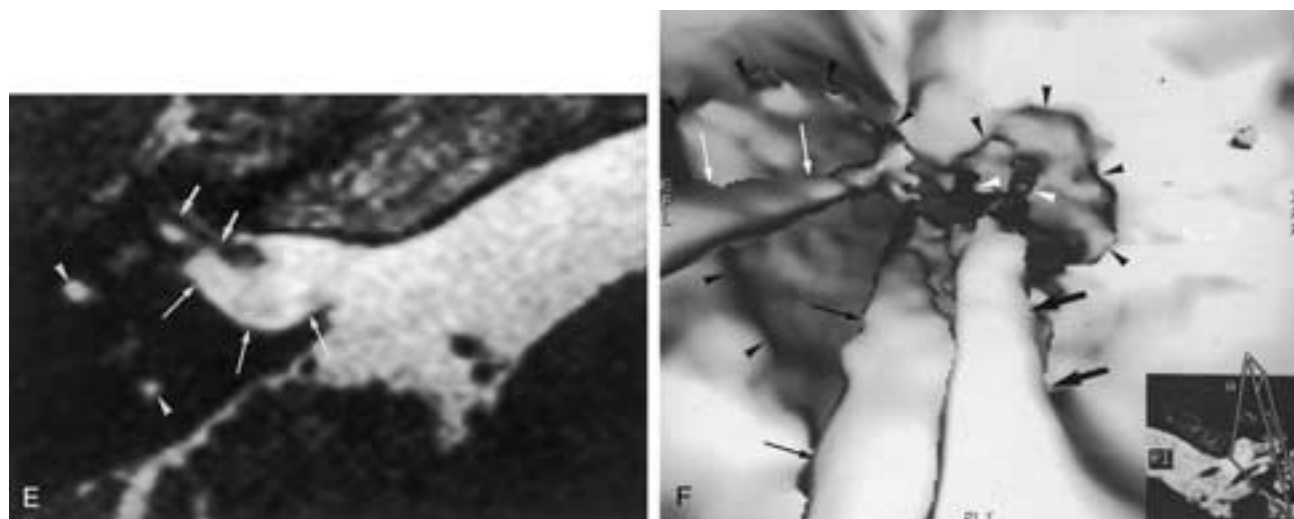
Continued.* E, Axial gradient-echo T2-weighted image through the enlarged labyrinthine segment of the facial nerve canal, confirming the presence of fluid surrounding the labyrinthine segment of the facial nerve (small white arrows). Wide, bulbous IAC (long white arrows) and fluid in the anterior and posterior branches of the superior semicircular duct (white arrowheads). F, Three-dimensional virtual images of the fundus of the right IAC, made by using 0.7 mm thick T2-weighted gradient-echo images. The facial nerve (long white arrows) can be seen inside the lateral part of the IAC and disappears in the facial nerve canal. The common vestibular branch (long black arrows) and cochlear branch (large black arrows) of the VCN can be followed in the IAC, and branches (spiral ganglia) of the latter nerve can be followed inside the cochlea (white arrowheads). One can look inside the abnormal cochlea, as no bony barrier exists between the IAC and the lumen of the cochlea. Defect in the base of the cochlea (black arrowheads).
